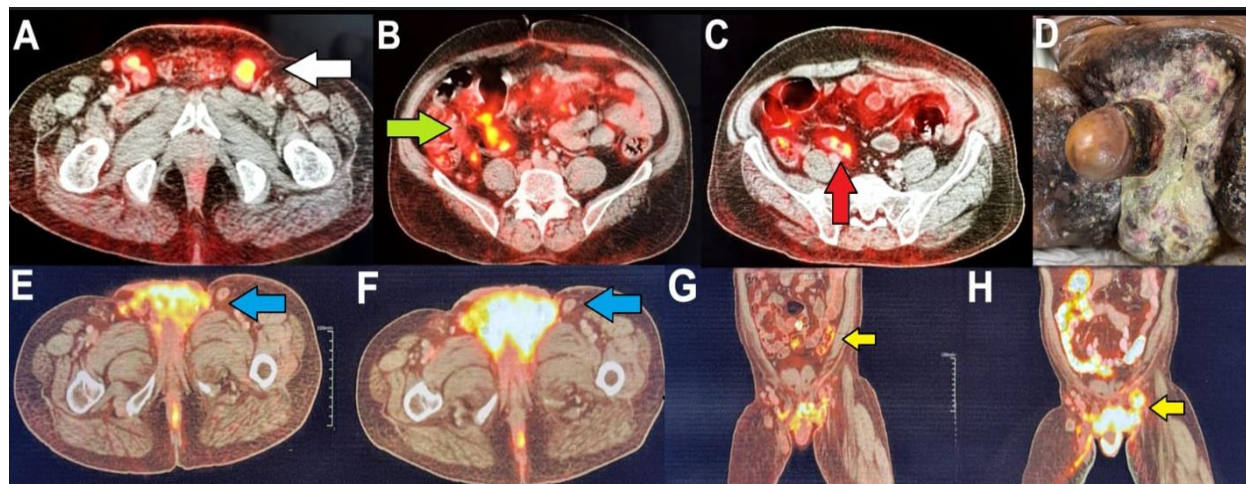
Postoperative recurrence and metastatic progression on 18F-FDG PET/CT.
